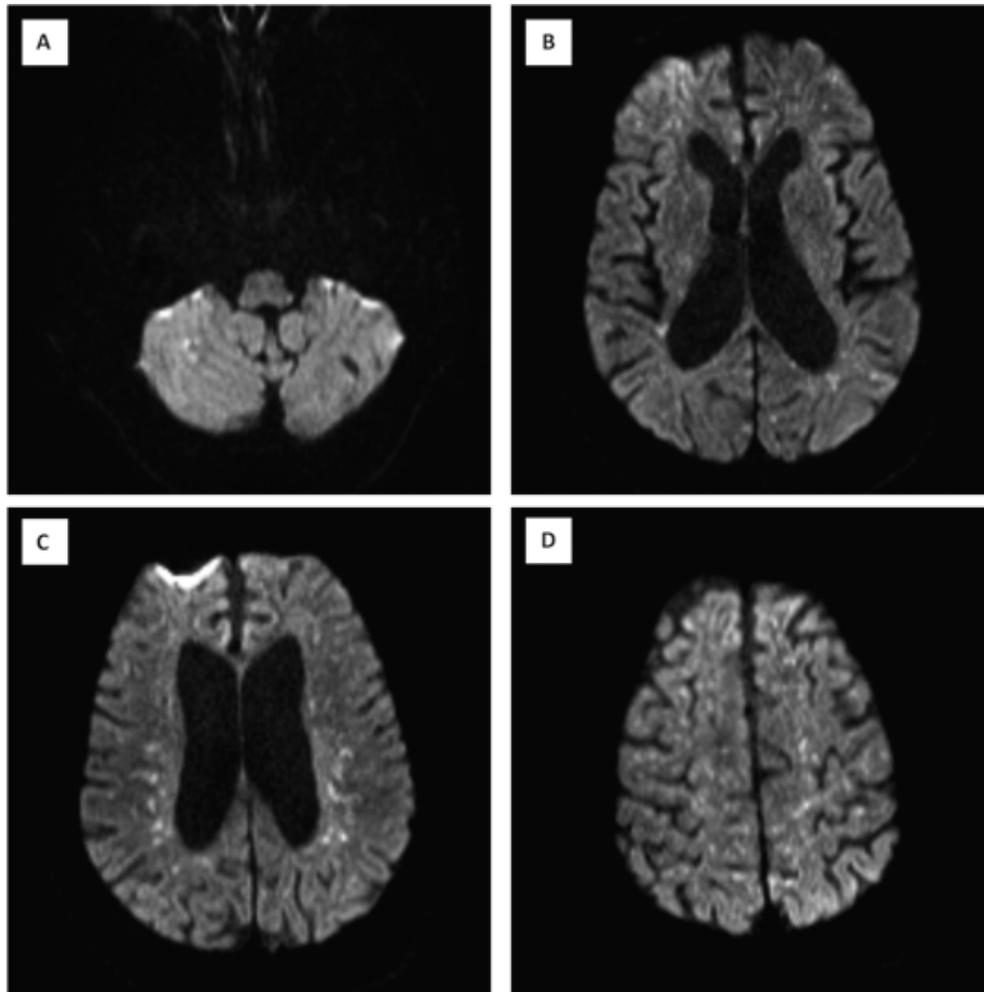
Select diffusion-weighted (B1000) MR images from initial presentation. Demonstration of innumerable punctuate foci of acute infarction (bright), including the regions of A) the right inferior cerebellum and B,C,D) the periventricular and subcortical white matter.
